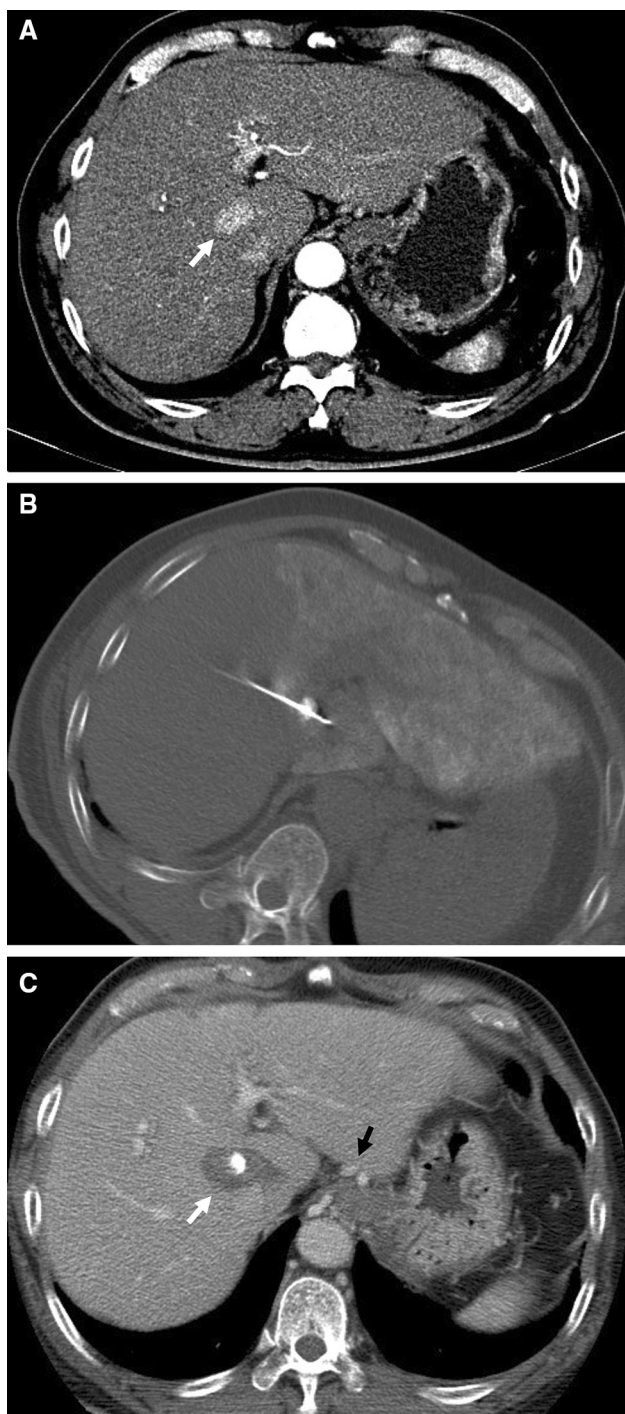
A 67-year-old male with HCV-related liver cirrhosis and HCC. A Axial arterial phase CT of the abdomen showed a 2.4-cm avid enhancing lesion (white arrow) in the caudate process of segment I with delayed phase washout (not shown), which was characteristic of HCC. B CT-guided RFA from a right intercostal lateral approach was performed after iodized oil targeting. C CT of the abdomen at 3-month follow-up shows complete ablation of the caudate HCC (white arrow). Note the gastroesophageal varices (black arrow). The patient died 2 years later due to variceal bleeding
